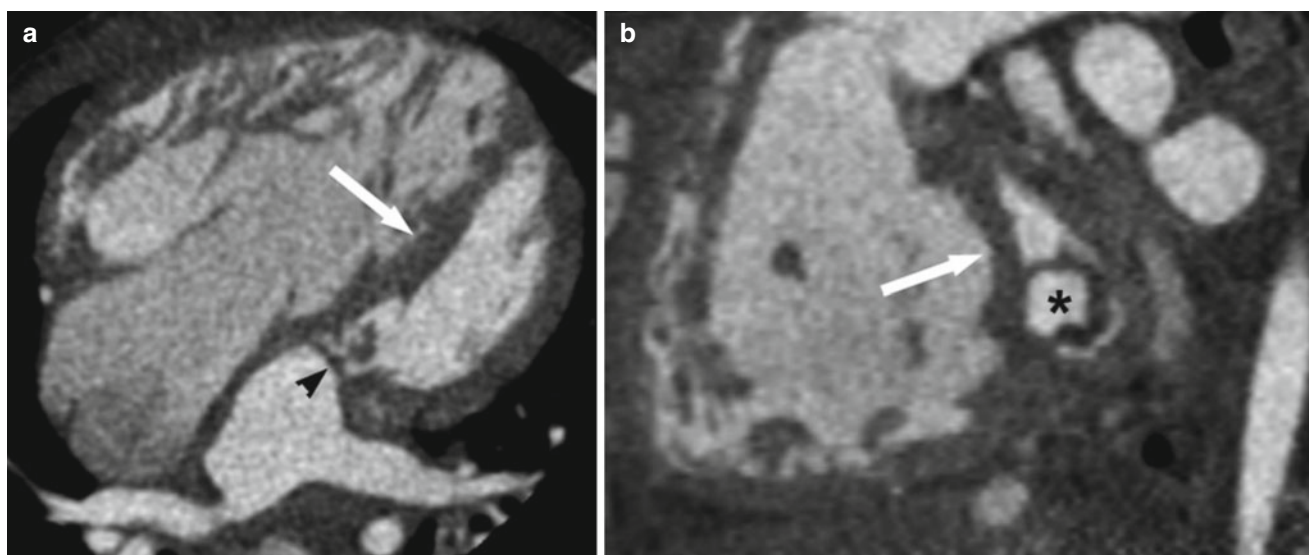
Four chamber (panel a) and short-axis (panel b) views of a contrast-enhanced CT scan in an young patient with congenital mitral stenosis (“parachute mitral valve”; *arrowhead* and *asterisk*) and secondary pulmonary hypertension. There is severe right ventricular
